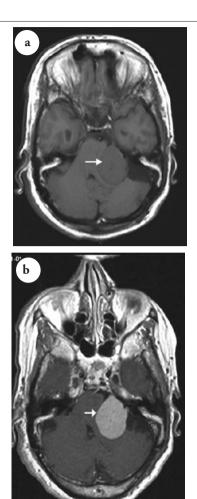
An MRI of the brain a) revealing left cerebellopontine angle (extra axial) mass lesion, isointense signal in T1. b) Same with brisk contrast enhancement post gadolinium injection picture implying left vestibular schwannoma.
